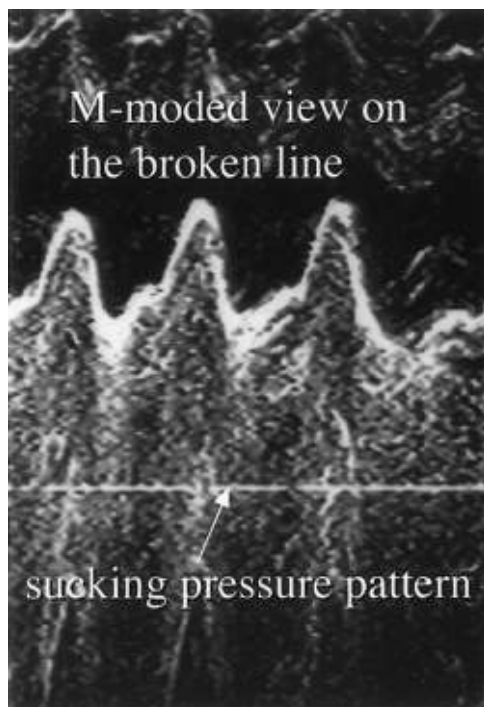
Sucking pressure pattern displayed with M-mode ultrasonograms during nutritive sucking. Sucking pressure pattern curves were always flat in the four neonates with cleft palate.
